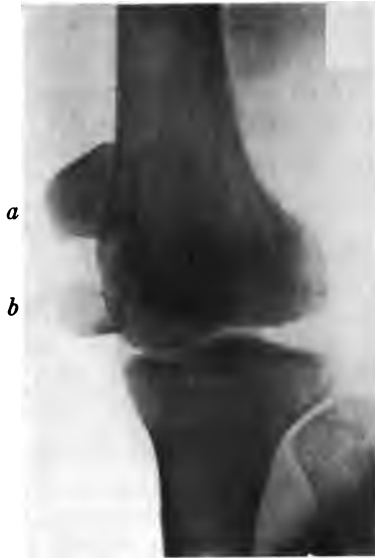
a*, Upper fragment widely separated from lower. *b*, Lower fragment tilted upward. Radiograph taken immediately after accident.
